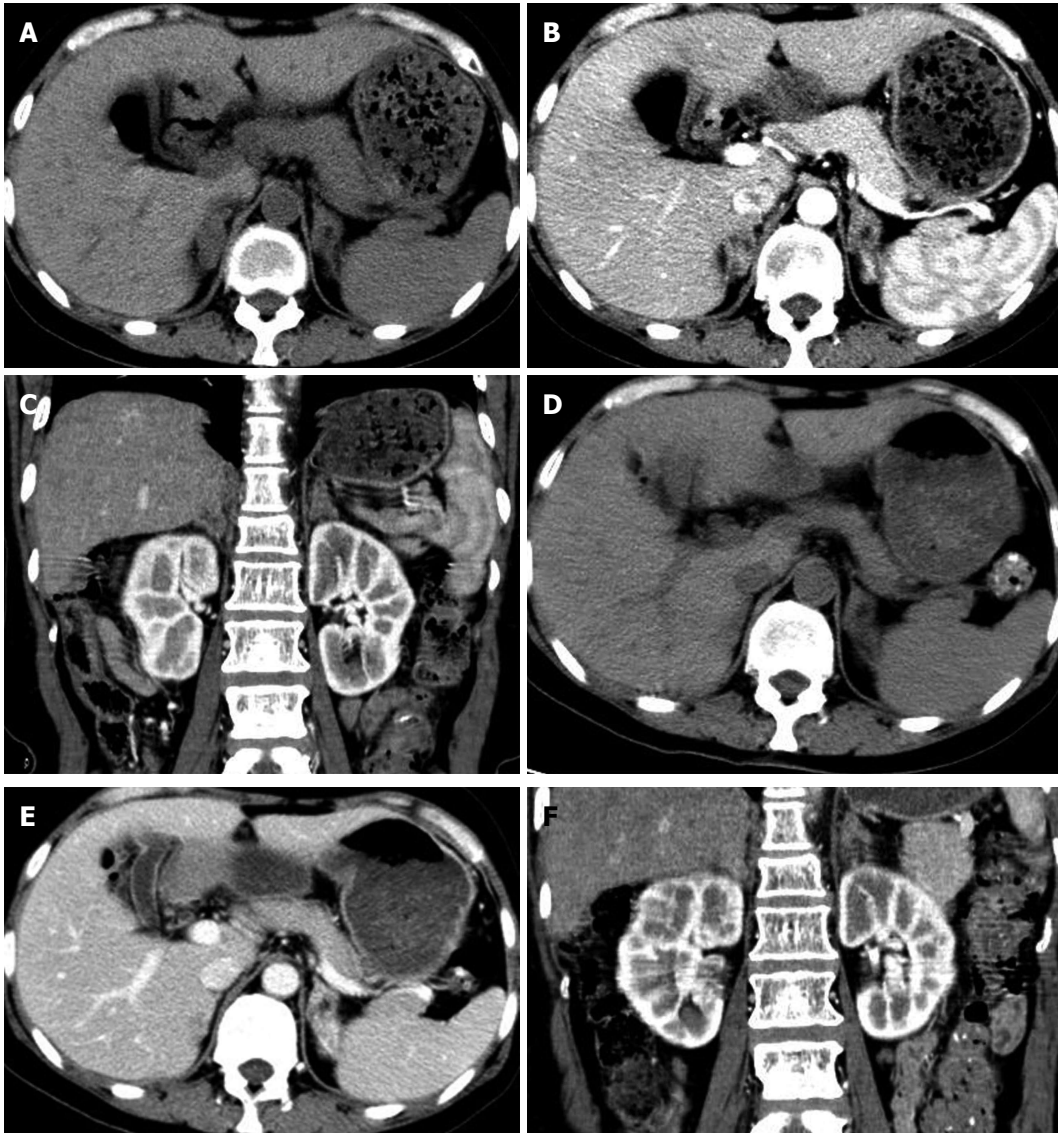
A 52-year-old woman who has anorexia, daytime somnolence and sweating in last three months with primary adrenal insufficiency due to adrenal tuberculosis. The unenhanced (A) and contrast-enhanced (B) CT scans reveal the mass-like enlargement of bilateral adrenals, but its contours are preserved with multifocal peripheral enhancement on axial (B) and coronary (C) reformed images. Three months after antituberculous therapy, the axial (D and E) and coronary (F) images demonstrate the initially enlarged adrenal glands become small with homogeneous density in the center, and decrease of probability of the presence of peripheral rim enhancement. CT: Computed tomography.
